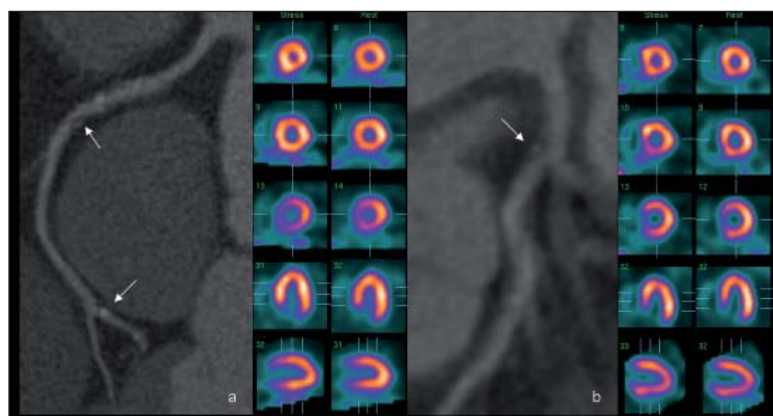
a. Mixed plaque in proximal and distal right coronary artery (arrows) with no evidence of flow-limiting disease on single photon emission computed tomography myocardial perfusion scintigraphy. b. Mixed plaque in proximal left anterior descending artery (arrow), also with normal single photon emission computed tomography myocardial perfusion scintigraphy.
